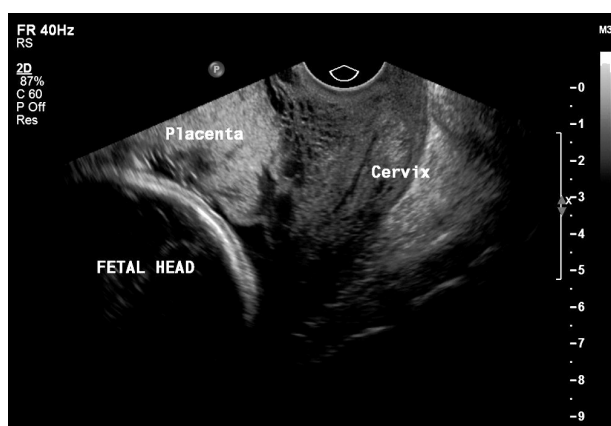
Ultrasound techniques used for diagnosis of placenta increta: note the invasion of the cervix by the placental tissue (a sponge-like zone in the upper central part of the image). See also the discussion of placental pathologies in Section 1.3.2. Reproduced from Abramowicz and Sheiner (2007)
